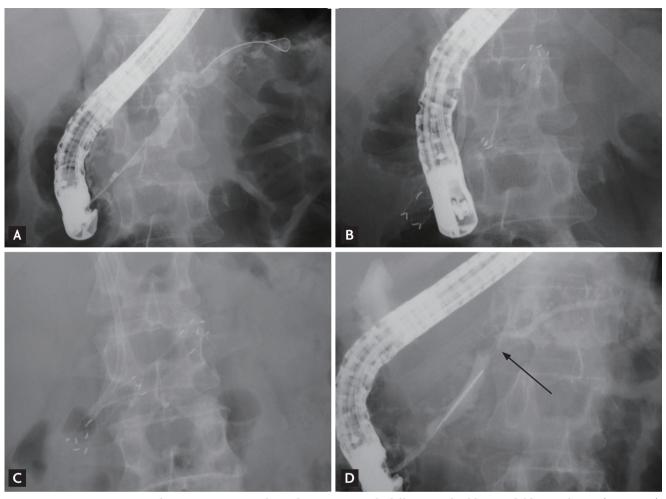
De novo* stricture at the main pancreatic duct after insertion of a fully covered self-expandable metal stent (FC-SEMS). (A) Pancreatographic image showing dilation of the main pancreatic duct with a stricture in the head of the pancreas. (B) Insertion of a FC-SEMS through the stricture of the main pancreatic duct. (C) Simple abdominal plain X-ray image showing the fully expanded FC-SEMS in the main pancreatic duct. (D) Follow-up pancreatography image showing the *de novo* stricture (arrow) just above the upper end of the previously inserted FC-SEMS.
